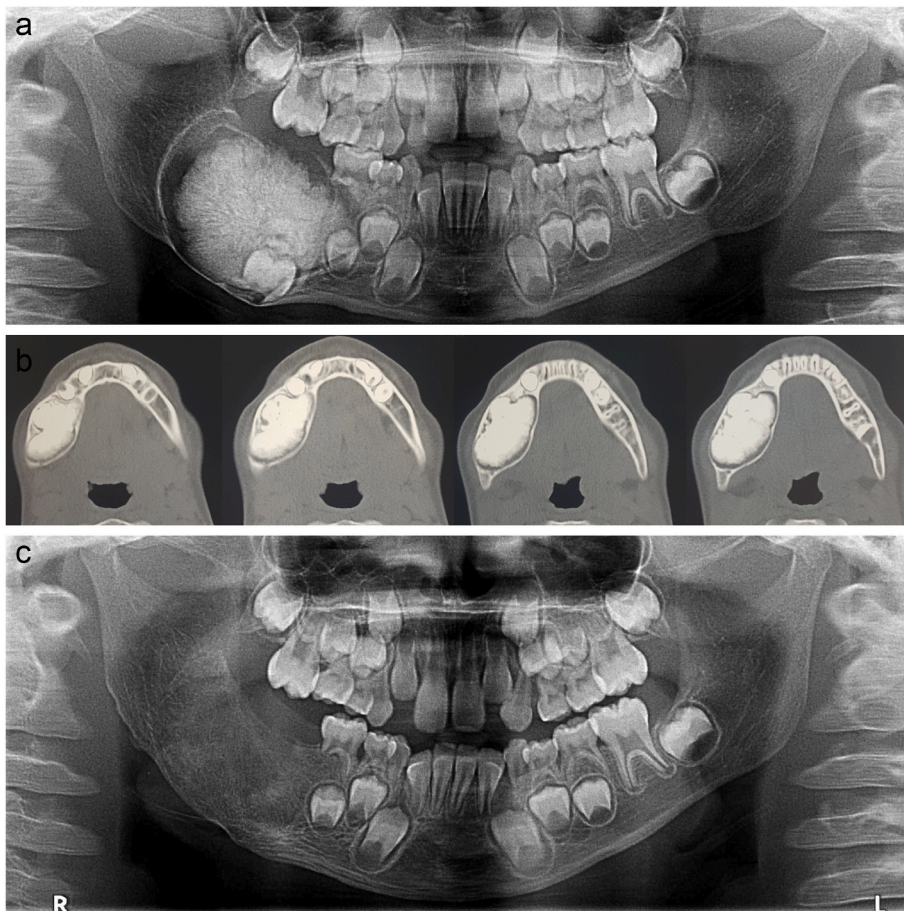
Large radiopaque lesion with clear radiolucent borders occupying the entire height of the mandibular body, displacing the mandibular inferior border and mandibular canal inferiorly, extending from the right premolars region towards the right ramus, and interfering with teeth eruption (a); Patient computed tomography (CT) images showing the lobular nature of the lesion, and clear expansion of buccal and lingual bone plates (b); Favorable bone healing was seen via 6-month follow-up panoramic x-ray (c).
